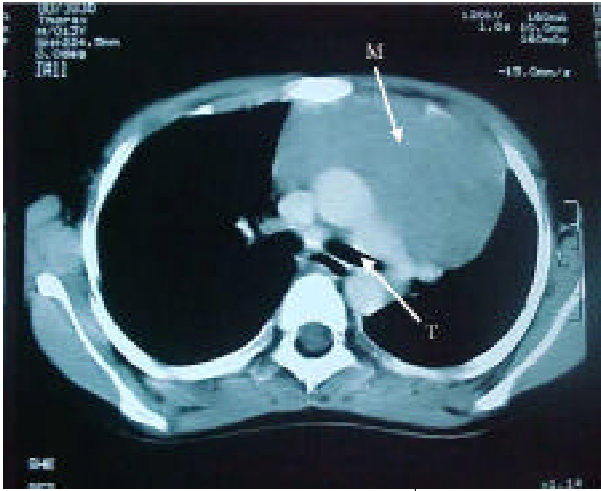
This computerized tomographic scan of the upper thorax shows a large anterior mediastinal mass (M) and compression and deviation of the trachea to the left (T). The CT scan was performed before surgery.
